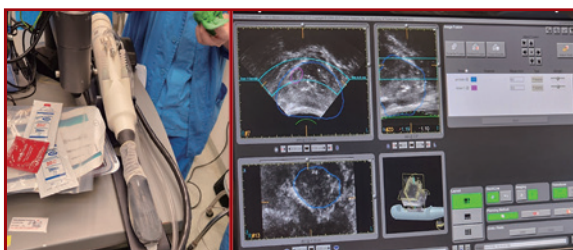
High-Intensity Focused Ultrasound. (Left) The HIFU probe, to be inserted into the rectum. (Right) A HIFU software interface depicting an axial ultrasonic view of the prostate, and the ablation zone (Clinical photos from personal collection)
